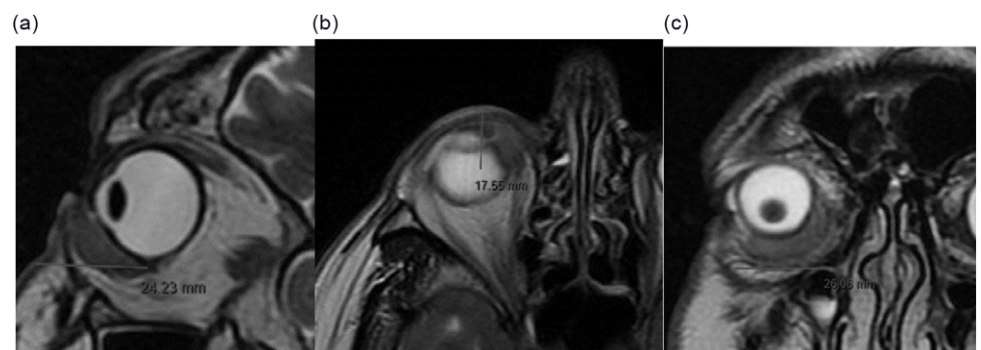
(a–c) MRI images show the localisation of the disease.
